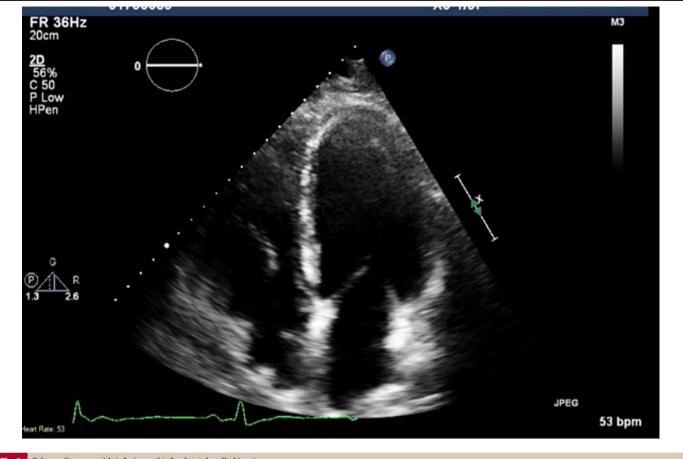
Echocardiogram with inferior and inferolateral wall akinesis.
